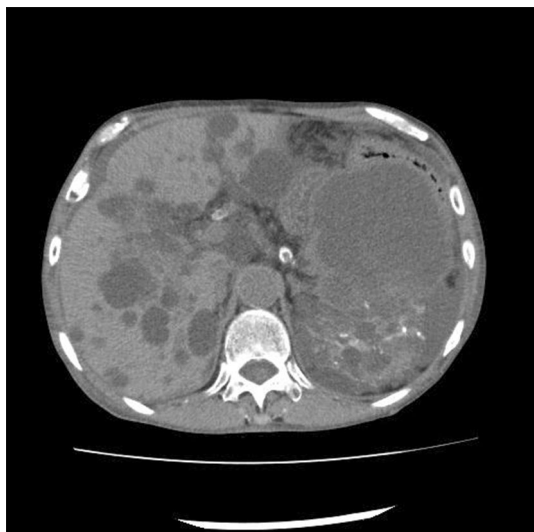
Initial abdominal CT scans. One of the renal cysts in the left kidney is shown as a slightly high density area compared with the other cysts
